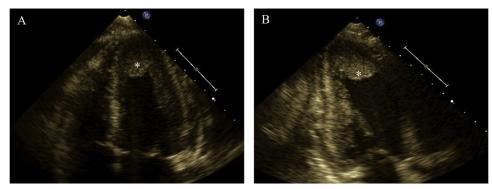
Transthoracic echocardiography, (A) apical four-chamber view and (B) apical two-chamber view, showing apical isoechoic density (asterisk) suspicious for left ventricular mural thrombus.
